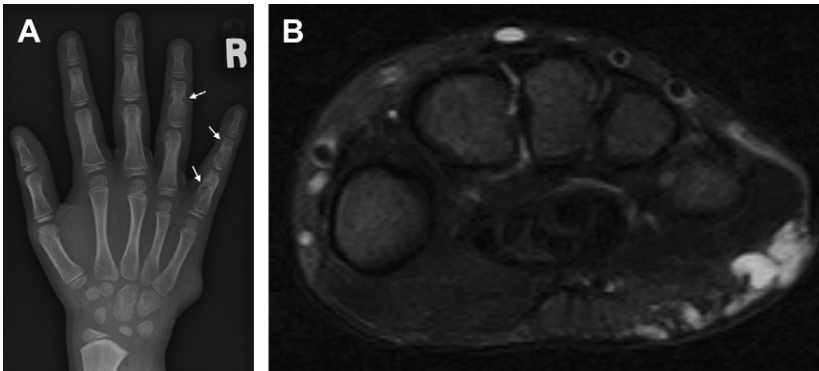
Maffucci syndrome in a 9-year-old boy. (A) Frontal radiograph of the right hand shows lucent bone lesions consistent with enchondromas (arrows), and soft tissue mass adjacent to the fifth metacarpal. (B) Axial fluid-sensitive sequence demonstrates the mass represents a venous malformation.
